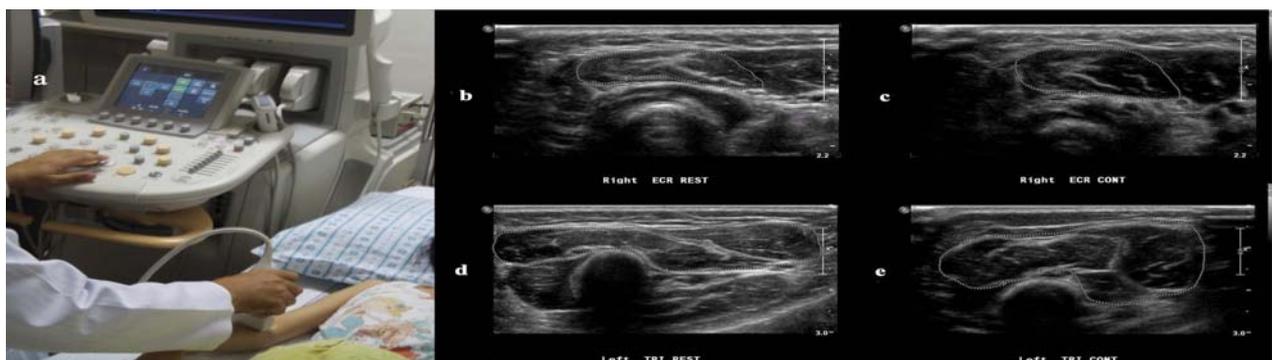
Ultrasound imaging set up and cross-sectional area (CSA) data. (a) Sonographic images were acquired with Philips iU22 ultrasound system using linear transducer (L7-12 MHz); (b) CSA of Rt. ECR at rest; (c) CSA of Rt. ECR at contraction; (d) CSA of Lt. TRI at rest; (e) CSA of Lt. TRI at contraction.
